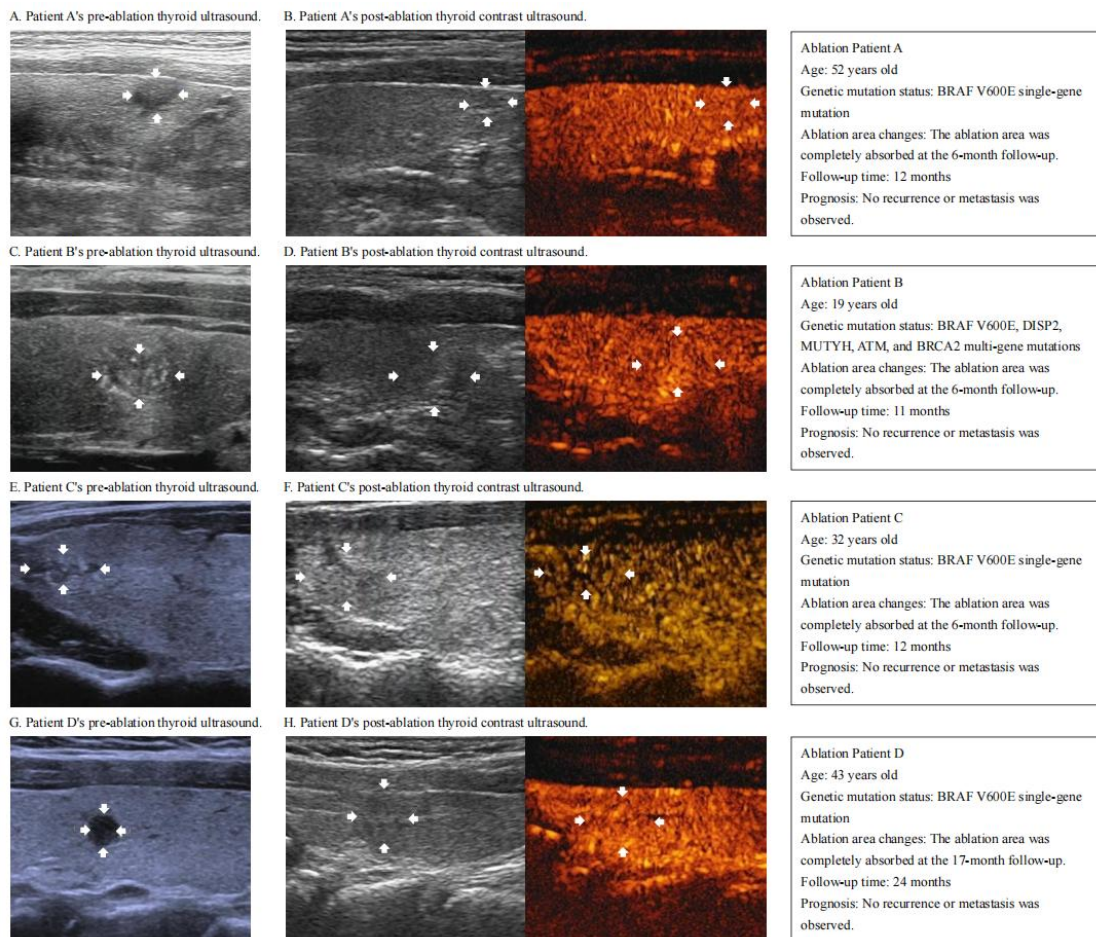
Ultrasound images for patients with thyroid carcinoma before and after Microwave ablation. A) Pre-ablation thyroid ultrasound of patient A. B) Post-ablation thyroid contrast-enhanced ultrasound of patient A. C) Pre-ablation thyroid ultrasound of patient B. D) Post-ablation thyroid contrast-enhanced ultrasound of patient B.
